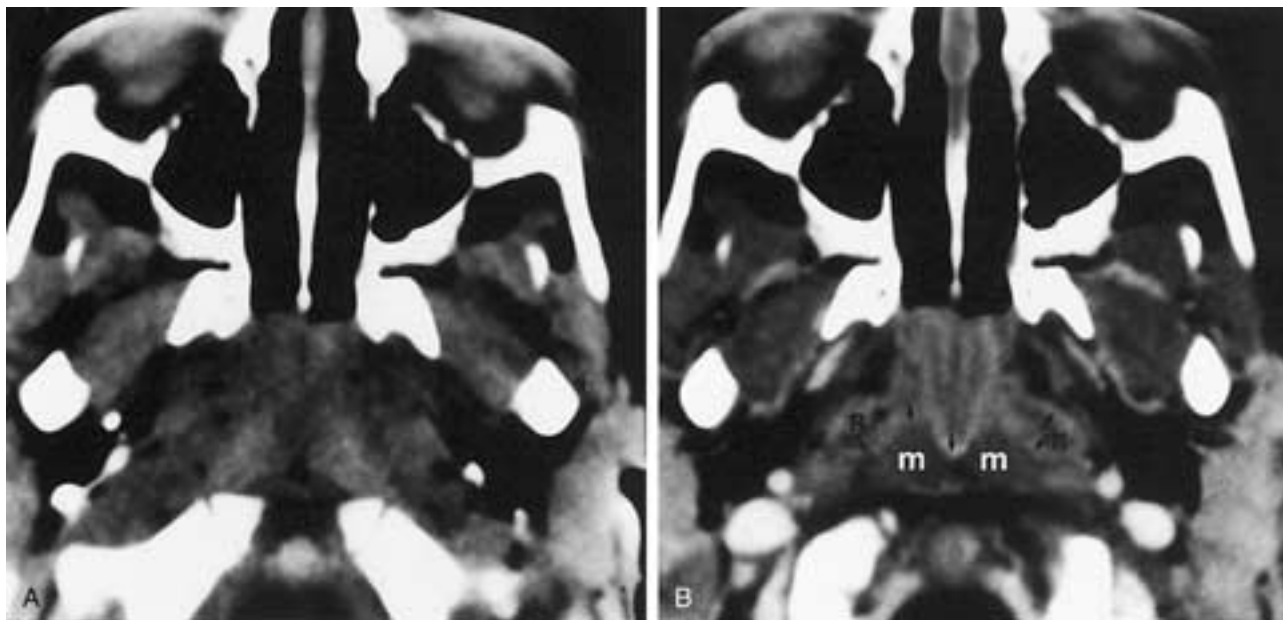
Normal adenoids on CT in a 14-month-old child. A, Axial noncontrast CT shows adenoidal tissue, nearly isodense to prevertebral muscles, filling the nasopharynx. B, Same child scanned following intravenous iodinated contrast administration using a spiral technique. The adenoidal tissue enhances, but prevertebral muscles (*m*) do not. Notice the thin linear enhancement at the interface between the adenoids and muscle (*black arrows*). The adenoidal tissue characteristically fills the lateral pharyngeal recesses (*R*), is flat ventrally, and does not extend into the deep pharyngeal spaces. (Courtesy of Dr. John J. Alarcon, Scottish Rite Children's Medical Center, Atlanta, Georgia.)
